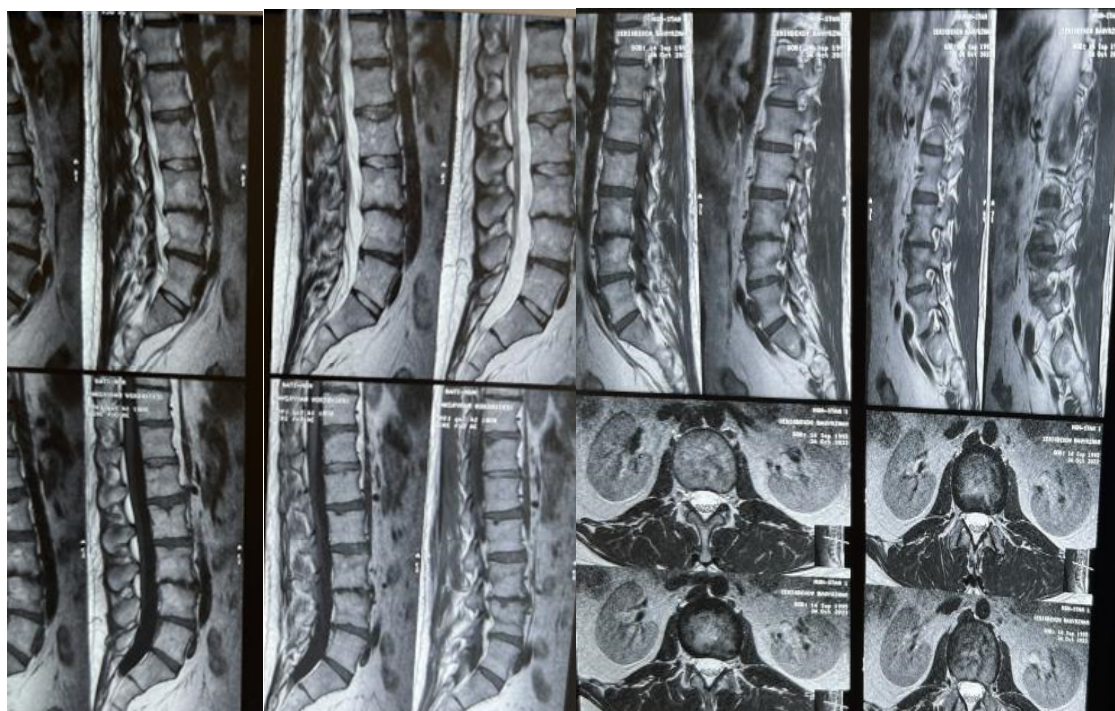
MRI of the spine patient No. 1, 10.2022. (after treatment) – osteochondrosis, central hernia L5-S1. Right-sided paramedian protrusion of the L1-L2 disc. Signs of spondylodiscitis at the level of L4-L5.
